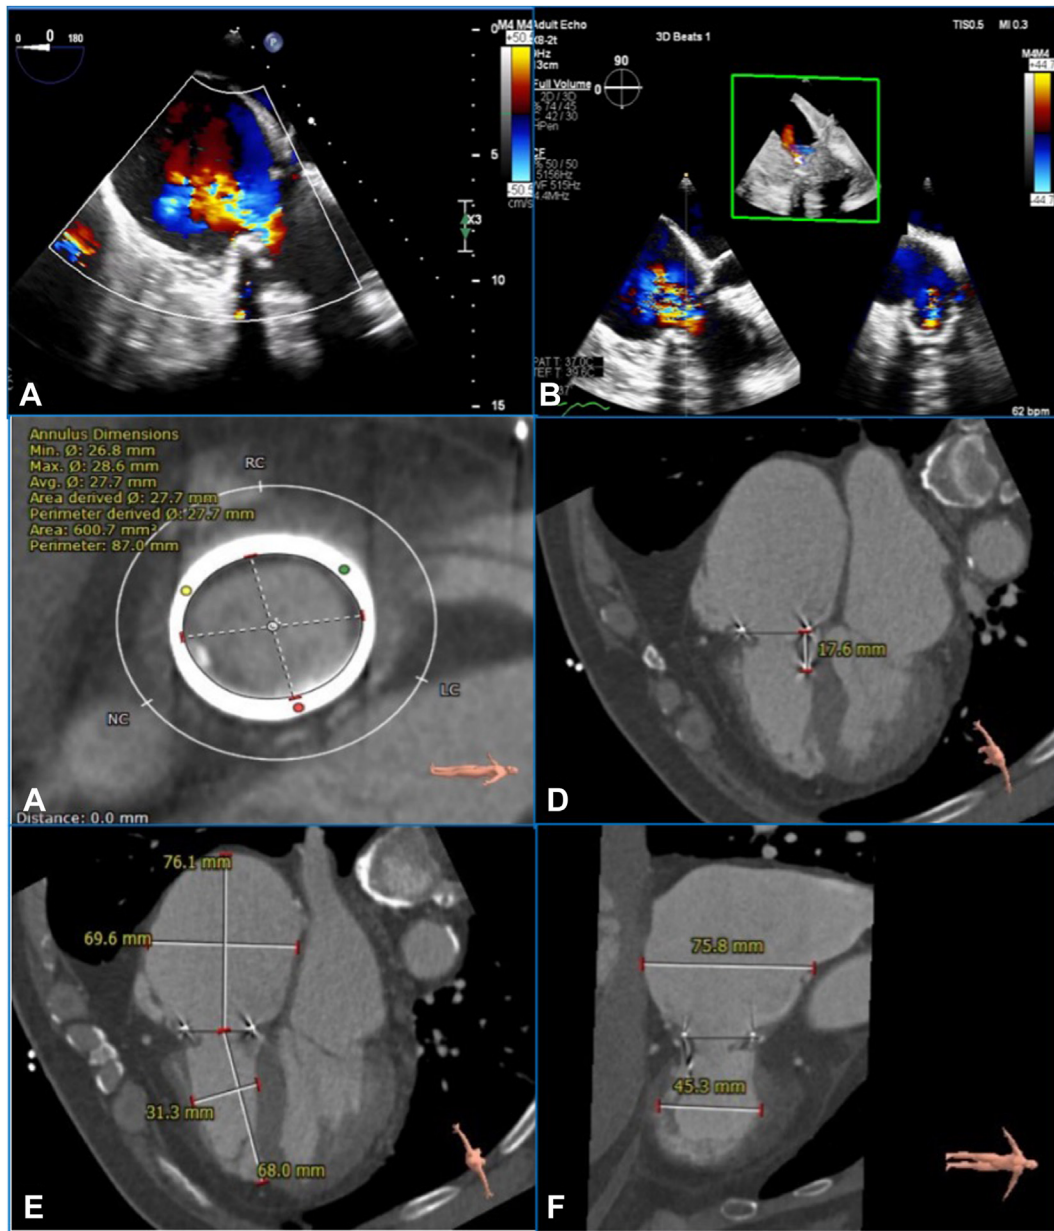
Preoperative assessment of transesophageal echocardiography and evaluation of computed tomography angiography using Circle Cardiovascular Imaging CVI42 software (Calgary, Alberta, Canada; eg, data for patient #3). (A,B) Preprocedural transesophageal echocardiography showed a large bundle of regurgitation in the tricuspid valve. (C) Annular area of the prosthetic tricuspid valve was 600.7 mm². (D) The annulus of the prosthetic tricuspid valve was 17.6 mm. (E) The right ventricle was 68.0 mm in the long axis, and 31.3 mm in the short axis, and the right atrium was 76.1 mm in the long axis, and 69.6 mm in the short axis. (F) The left and right axes of the right ventricle and right atrium were 45.3 mm and 75.8 mm, respectively.
